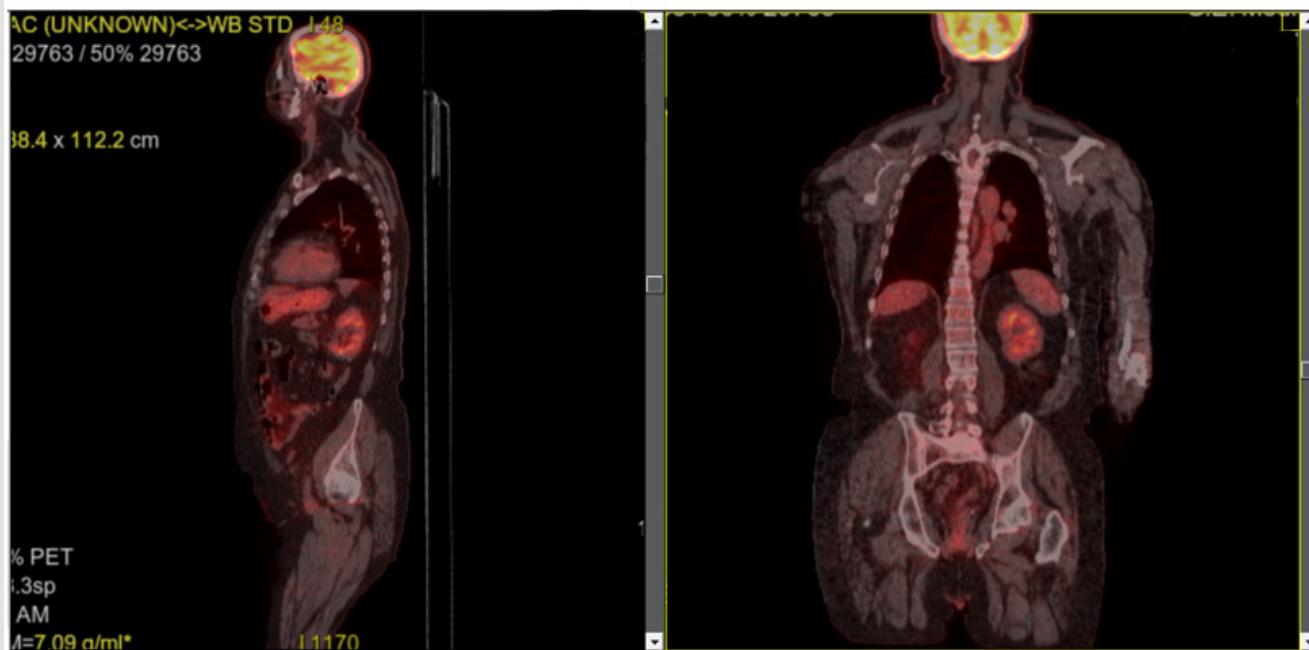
PET-CT scan performed in the context of post left partial nephrectomy. Beam-hardening artifacts are present at the surgical site, limiting evaluation to some extent. No focal FDG uptake is identified in the left renal region to suggest local recurrence.
